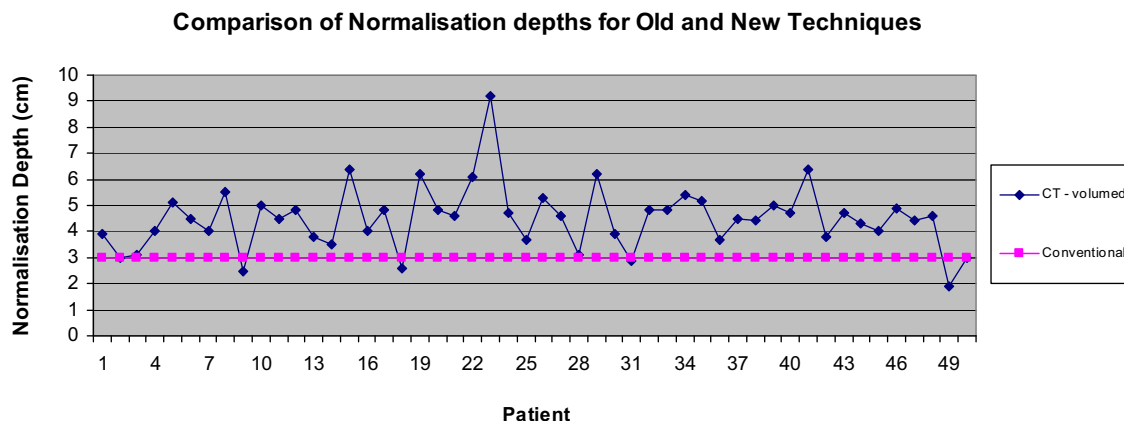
Comparison of normalisation depths for the conventional and CT volumed techniques.
